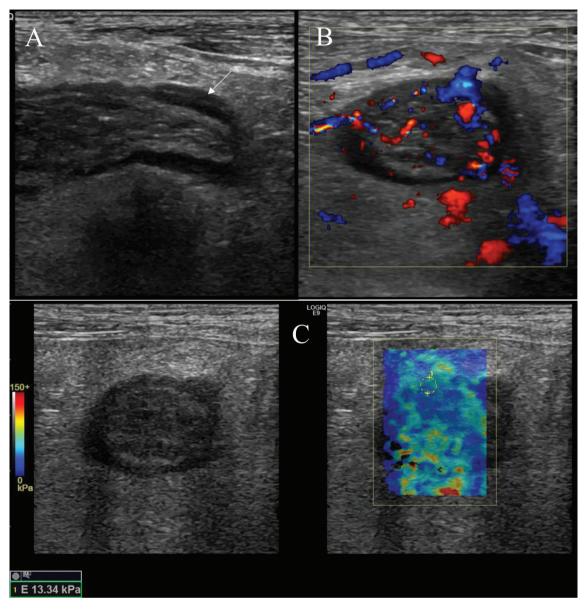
US image of a 38-year-old woman with active ulcerative colitis. (A) US image of the rectosigmoid colon showing a thickened bowel wall (arrow). (B) Color Doppler US image of the rectosigmoid colon showing Doppler signals in both the intestinal wall and the surrounding mesenteric fat (Limberg score: Grade 4). (C) SWE measurements of the rectosigmoid colon were obtained using a circular ROI placed on the bowel wall. The 2D-SWE map (right side) and grayscale image (left side) are shown. (US: Ultrasonography, SWE: Shear wave elastography).
